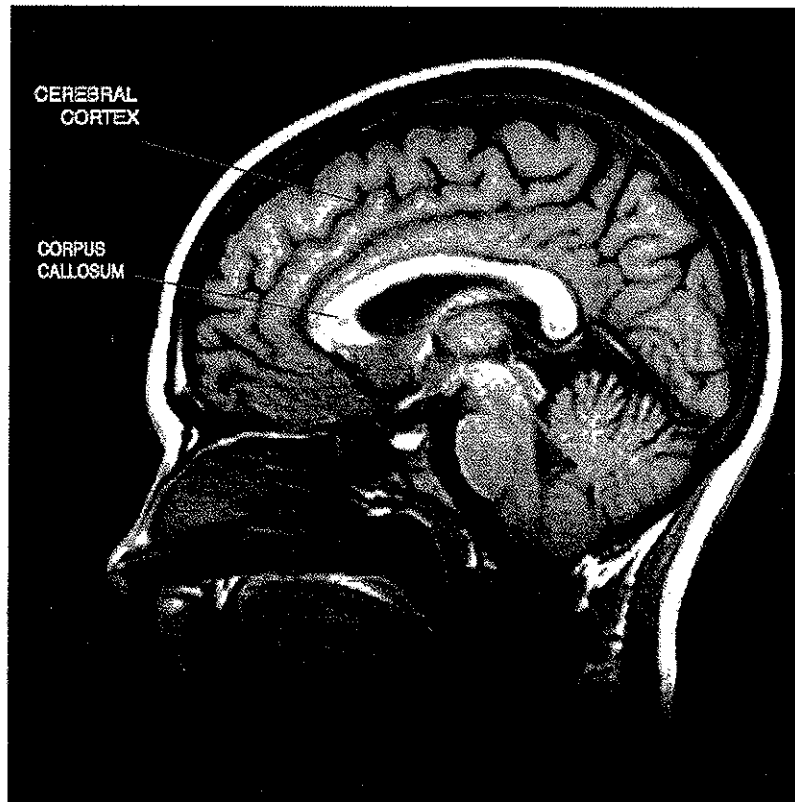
An MRI image of a mid-sagittal section of a human head. The convolutions of the cerebral cortex and the corpus callosum are clearly visible. (Courtesy of Isabel Gautier)
